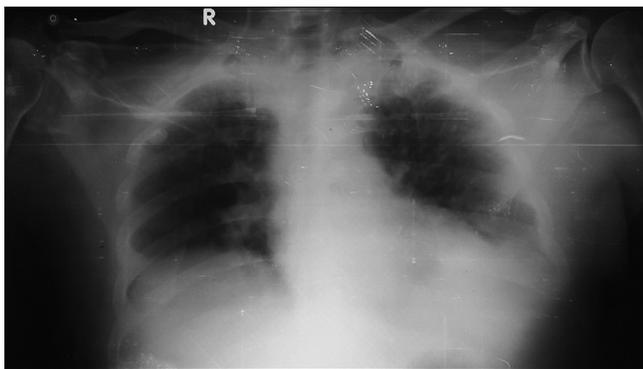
Chest X-ray showing central venous catheter inserted in the right subclavian vein, tip positioned in the right internal jugular vein
